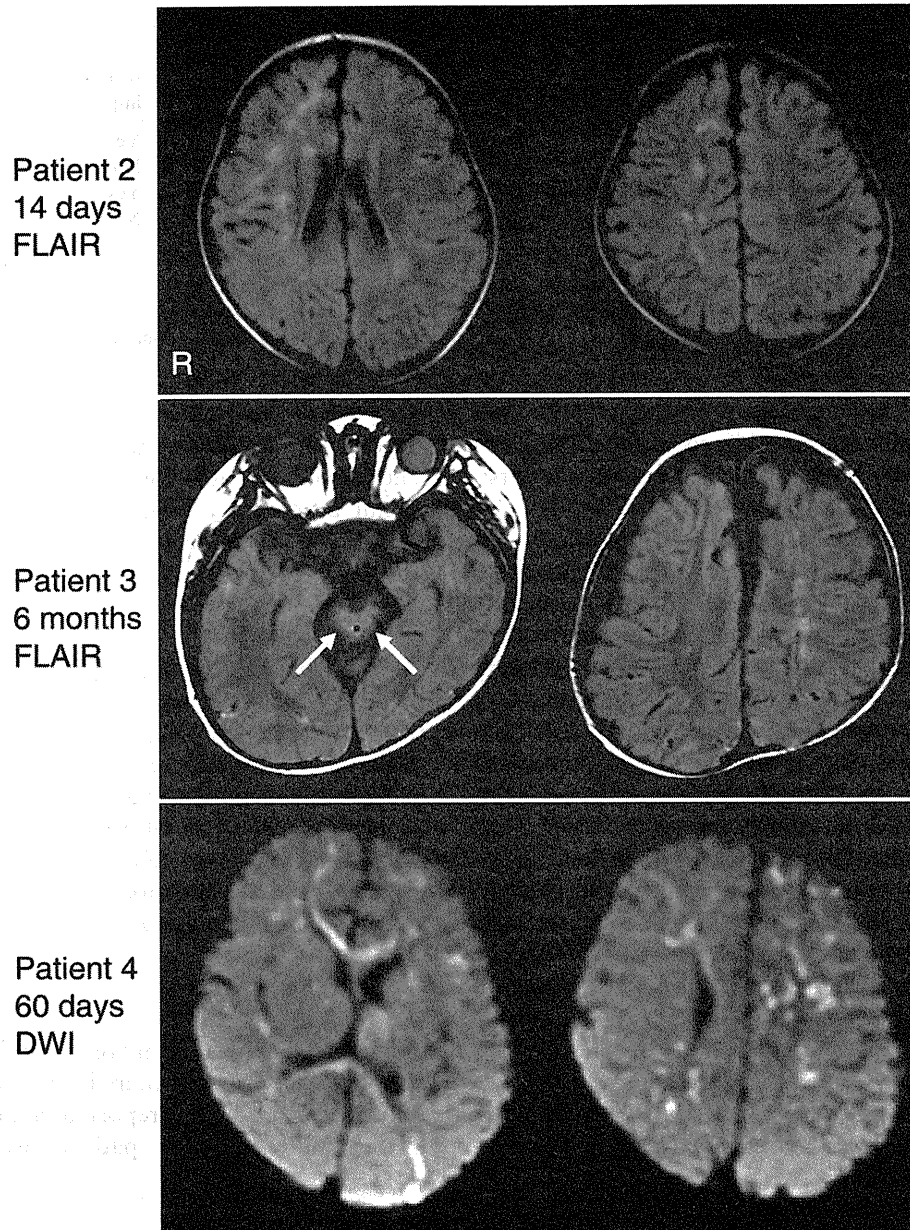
MRI findings during the acute stage of encephalopathic manifestation. Top: FLAIR of Patient 2 at 14 days of age. Patchy high-intensity areas were seen in the subcortical areas predominantly in the right hemisphere. Middle: FLAIR of Patient 3 at 6 months of age. Linear high intensities were observed in the dorsal area of the brainstem (arrows). Patchy high-intensity areas were also present in the subcortical areas of the left hemisphere. Bottom: DWI of Patient 4 at 60 days of age. Patchy restricted diffusion was recognized in the subcortical areas and corpus callosum. FLAIR, fluid-attenuated inversion-recovery images; DWI, diffusion-weighted images; R, right.
